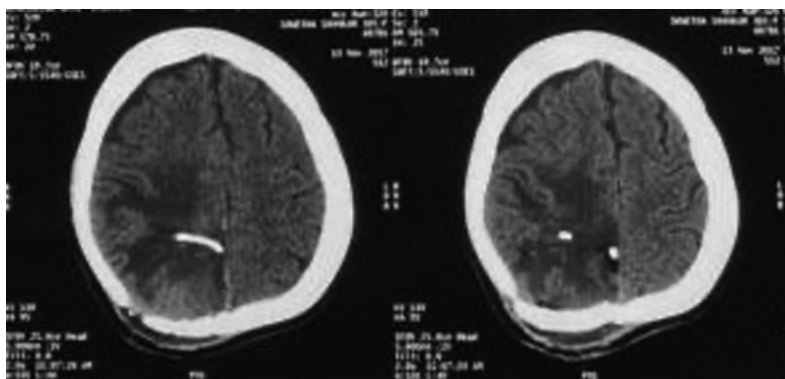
Computed tomography scan of the brain showing the catheter in situ in the excised tumor's cavity.
